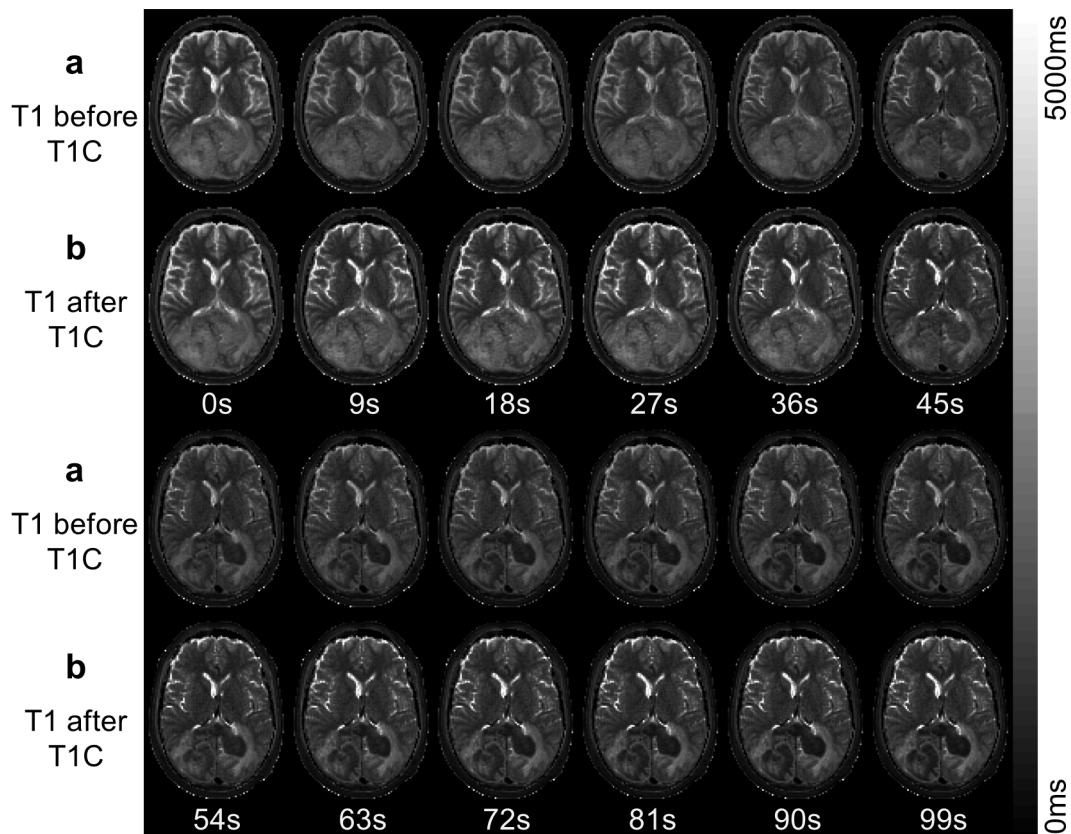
Clinical DCE-MRI example. Depicted are the first 12 IR frames of a dynamic T_1 mapping experiment performed on a patient with primary lymphoma. Shown are the uncorrected T_1 maps after the IR-MAP reconstruction (a) as well as the corrected T_1 maps after the application of T1C (b). Modified Figure from [93].
